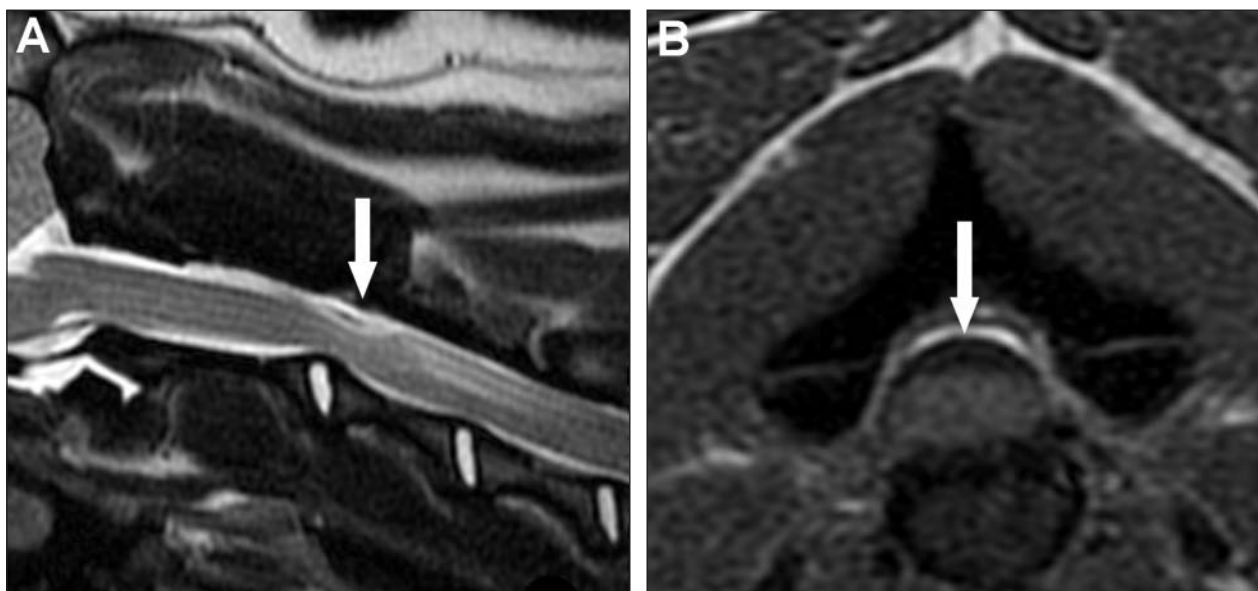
Magnetic resonance images of the cervical portion of the vertebral column and caudal portion of the brain of a 1.5-year-old Pug that was evaluated because of a 6-month history of progressive tetraparesis. A—A T2-weighted sagittal magnetic resonance image of the caudal portion of the brain and the C1 through C5 segments of the spinal cord. Notice the dorsal compression of the spinal cord by the cyst (arrow). There is also an area of hyperintense streaking just caudal to the cyst at the level of the C3-4 intervertebral space, which was identified as a mild syrinx. B—A T1-weighted axial magnetic resonance image of the cervical portion of the vertebral column at the level the C2-3 intervertebral space. The cyst (arrow) appears hypointense, compared with the spinal cord.
